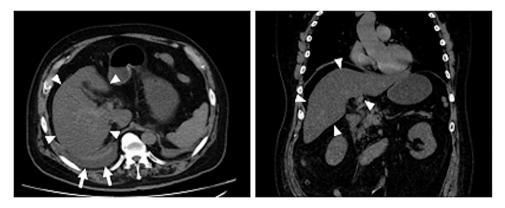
Simple computed tomography scan. Axial and coronal slices are shown. Arrowheads indicate atrophic liver and arrows indicate ascites and pleural effusion.
